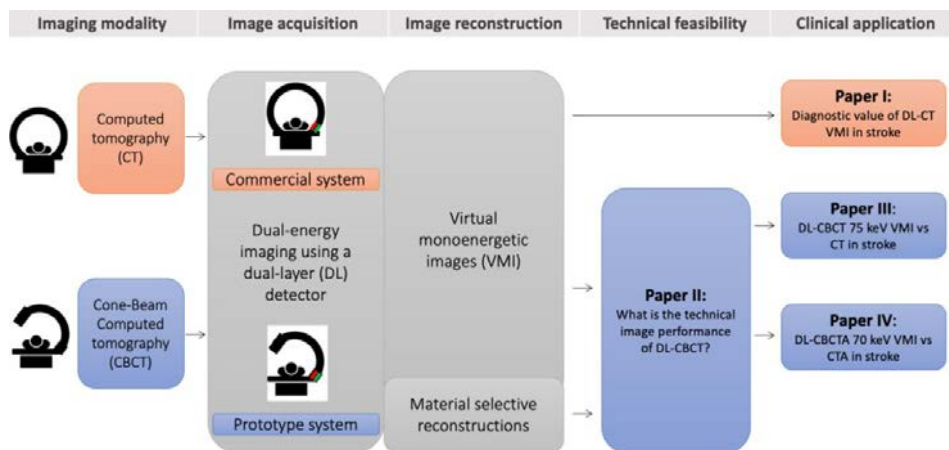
A visualization of the papers included in this thesis and their relationship to each other, with a brief description. DL-CBCTA = Dual-layer CBCT angiography, CTA = CT angiography.
